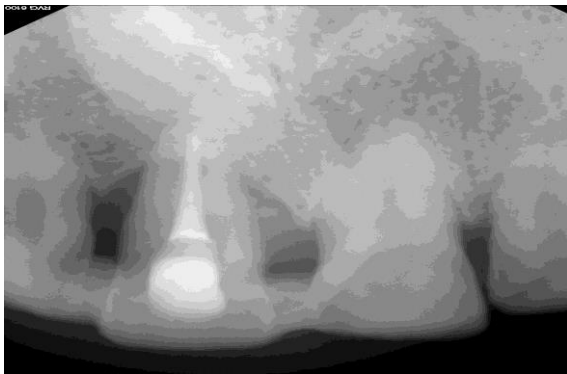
12th month radiograph
